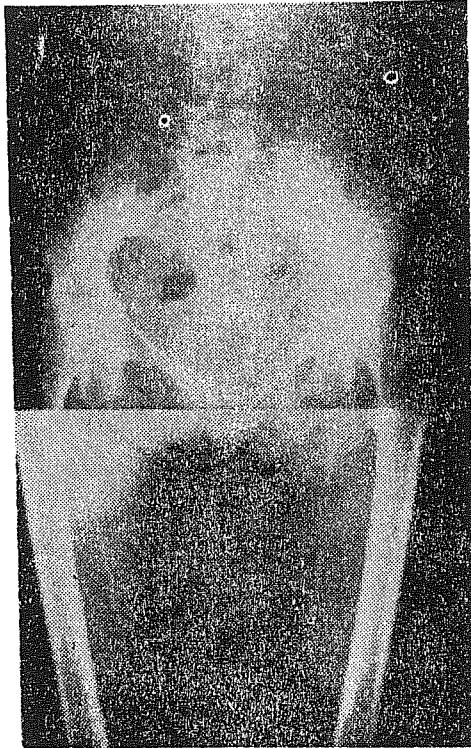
Postoperative plain roentgenogram showed almost same appearance of the iliac and femoral arteries as preoperative roentgenogram.
